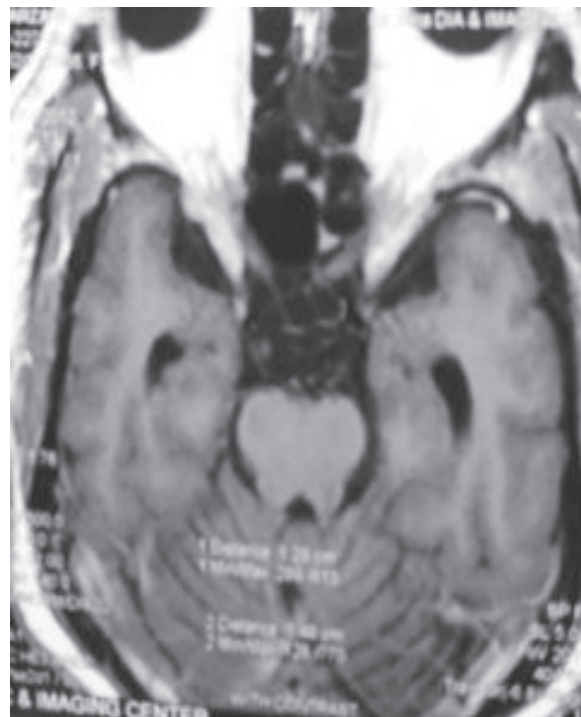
Postoperative MRI of brain (axial view)
